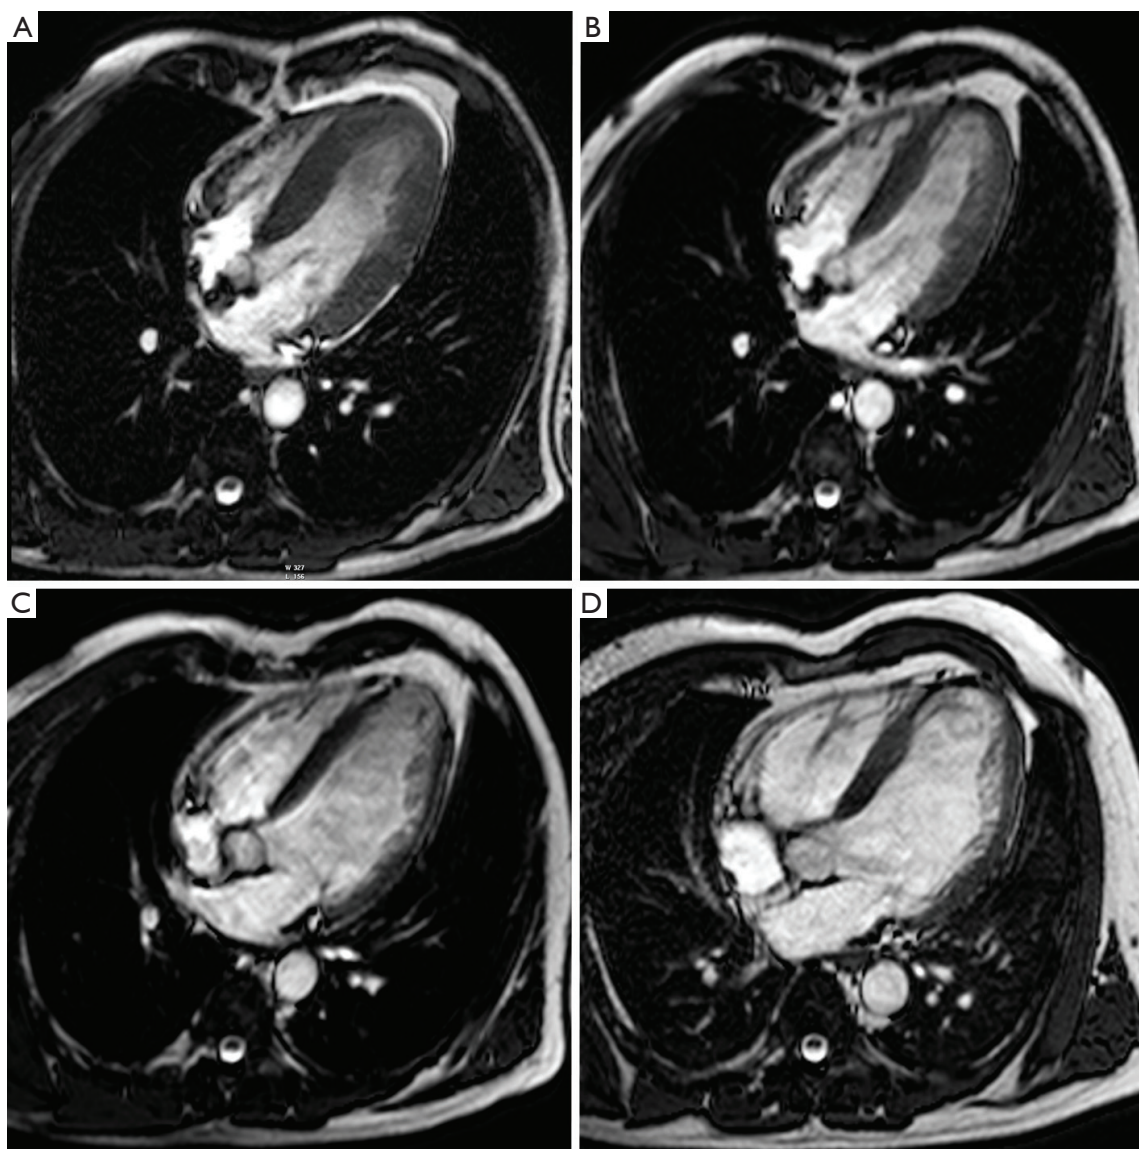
Use of MRI for long-term follow-up of ventricular remodeling post myocardial infarction in a patient with an extensive anteroapical MI. Horizontal long-axis cine imaging at 1 week (A), 4 months (B), 1 year (C), and 5 years (D) after the acute event (end-diastolic time frames). Cine imaging allows to appreciate the infarct healing with thinning of the LV apex, and the progressive LV dilatation over time (A-D). The LV end-diastolic volumes at 1 week, 4 months, 1 year and 5 years are 167 mL, 180 mL, 230 mL, 257 mL respectively. Adapted from *Ischemic Heart Disease* by Bogaert J and Dymarkowski S, in *Clinical Cardiac MRI Second Edition*, Bogaert J, Dymarkowski S, Taylor AM, Muthurangu V (eds). Springer Heidelberg, Germany (ISBN 978-3-642-23034-9)
